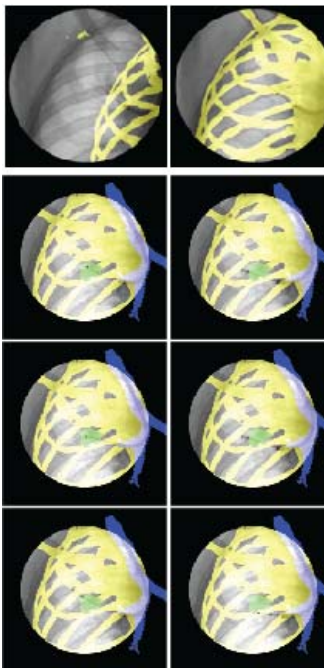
(Upper left): X-ray fluoro images acquired from a clinical PLL procedure. Yellow bone meshes from CT are overlaid on the fluoro image. Retrospective registration adapts from the initial position (left, SRE 41mm) to the final position (right, ERE 3mm) in ~3.5 seconds accelerated by GPU.
